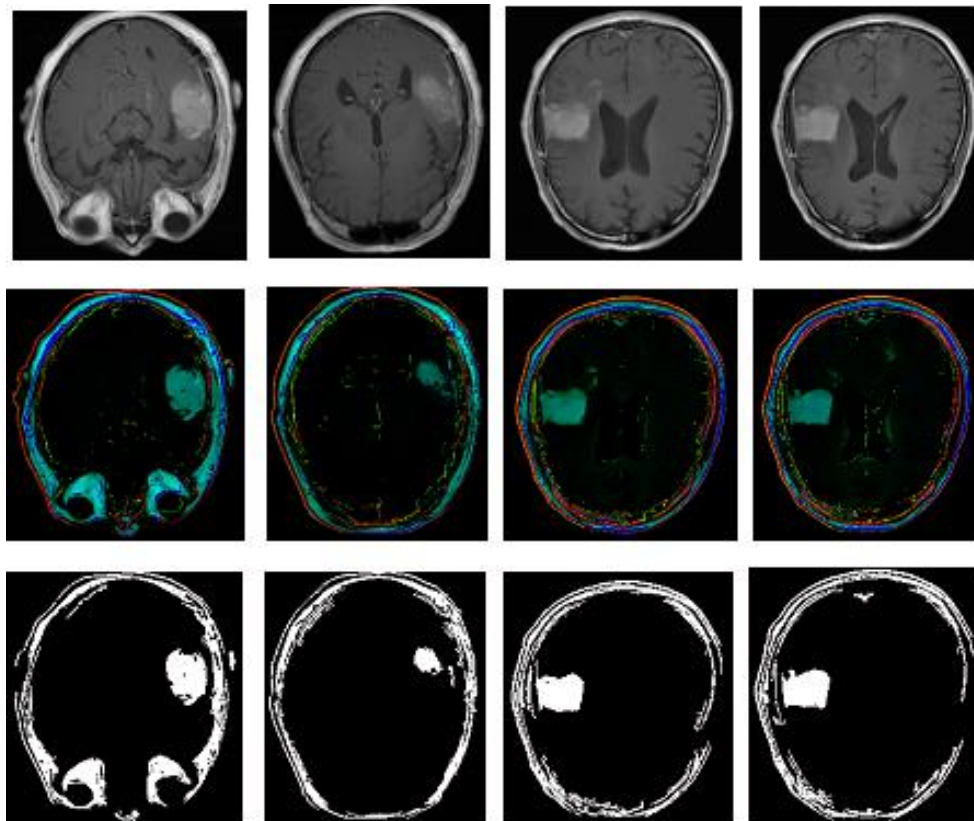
Brain tumor detection results: original T1-W MR images (1st row), the respective signature maps generated using the proposed scheme (2nd row), and respective segmented images (3rd row).
